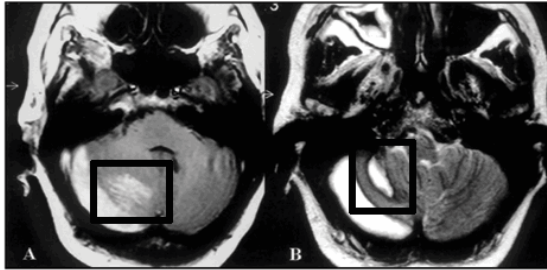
Intracerebellar hematoma – MRI screening
